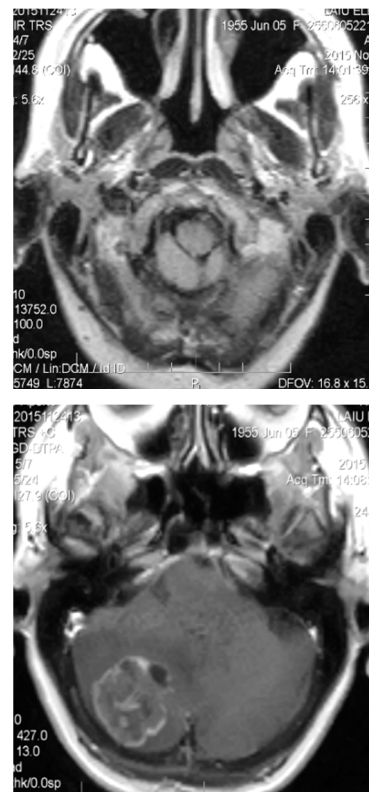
Case 2 – MRI T1 enhanced-tonsils herniation due to a large lesion at the level of the right cerebellar hemisphere
